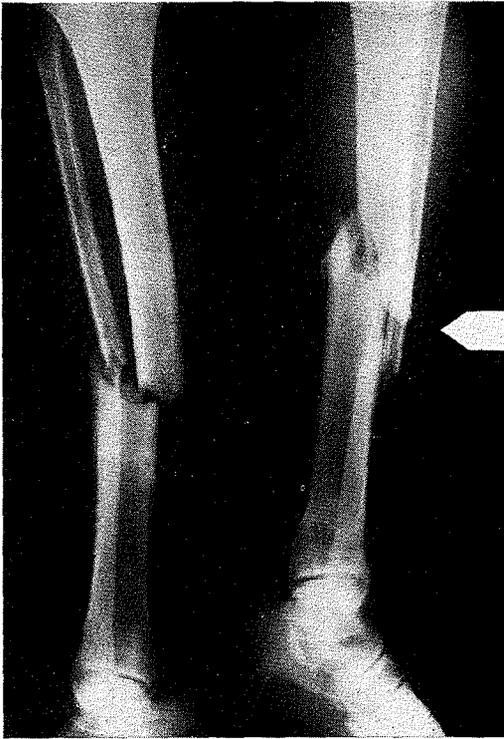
Case 0276: X-ray showing fractures of both tibiae
